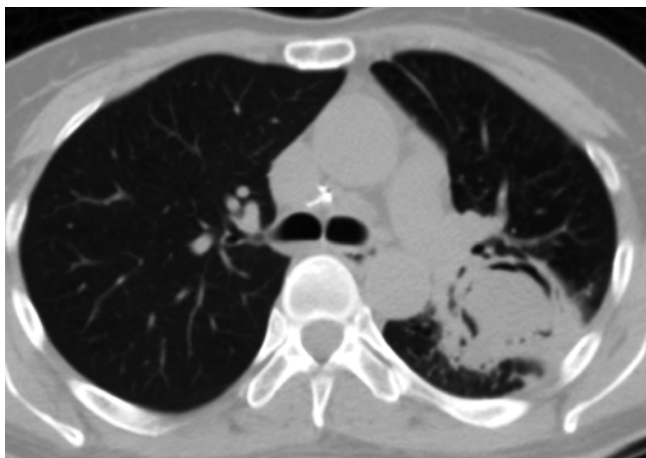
Aspergilloma. Axial CT image of a 17-year-old girl with a soft tissue mass (aspergilloma) within a cavity in the left upper lobe, forming the “air-crescent sign”
